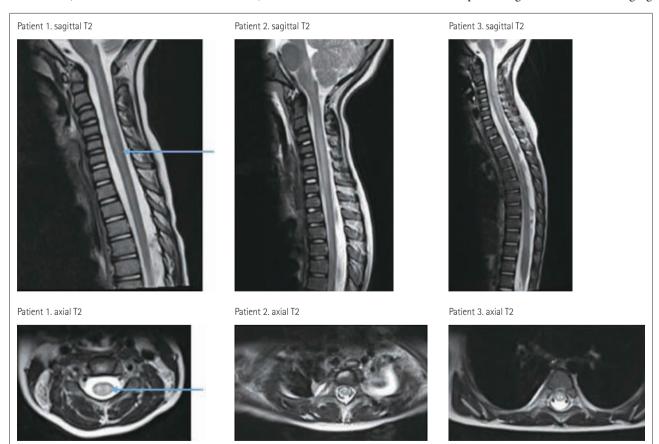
Representative MRI images of the spinal cord in AFM. Spinal MRI (T2-weighted saggital and T2-weighted axial) images of three children (confirmed as enterovirus-D68-associated AFM) showing hyperintensity in central gray matter (blue arrows). The parents of these children consented to the publication of these anonymized images (figure courtesy of Jay Shetty, The University of Edinburgh, Scotland, UK). AFM: acute flaccid myelitis, MRI: magnetic resonance imaging.
